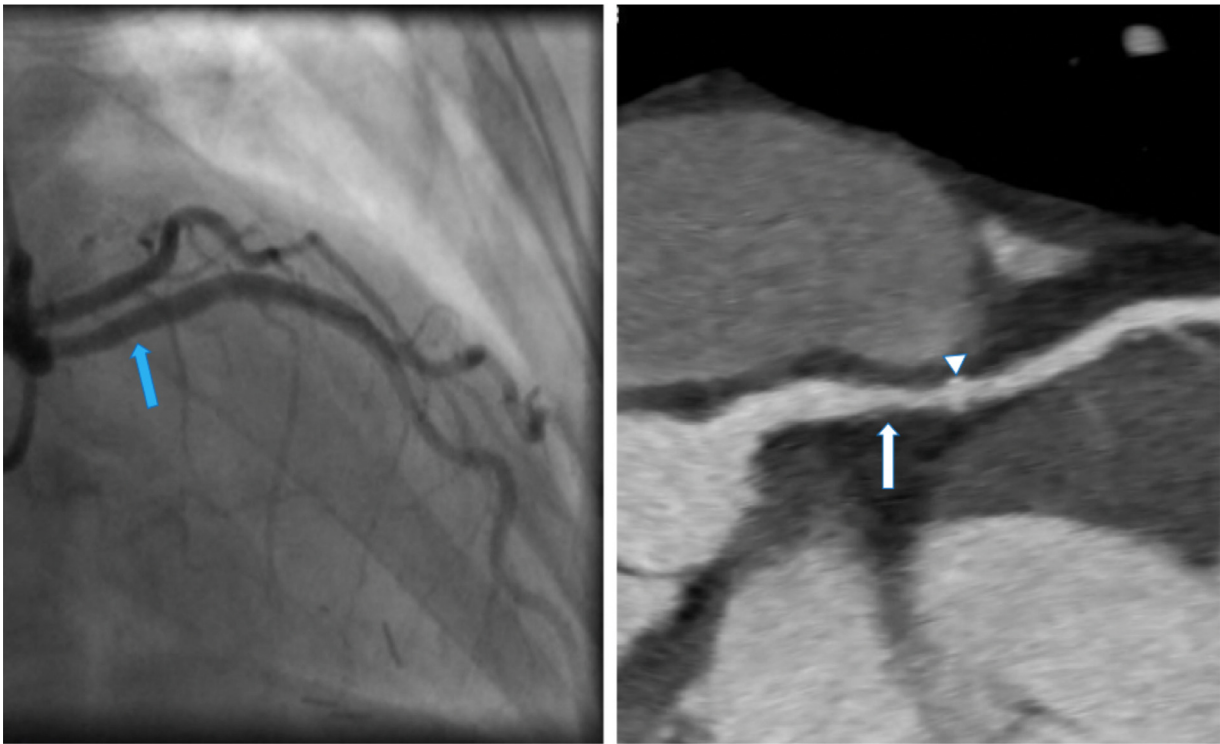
Coronary angiography compared to CCTA in the same patient. CCTA demonstrates high risk plaque features of positive remodeling (white arrow), spotty calcification (arrowhead), compared to same segment in LAD that appears normal using coronary angiography (blue arrow). CCTA = coronary computed tomographic angiography.
